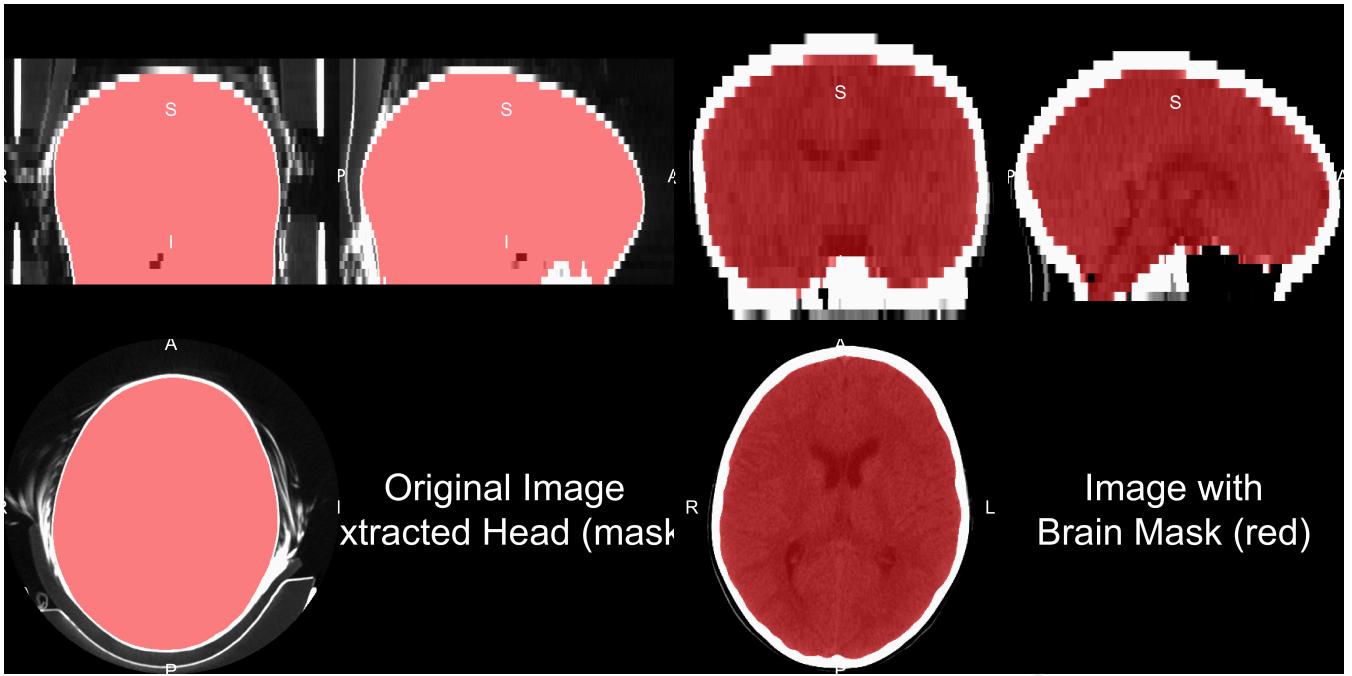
Human and Brain Extraction Results. Here we present a 5mm slice, non-contrast head CT with a soft-tissue convolution kernel. The left figure represents the CT image, showing all the areas imaged, overlaid with the extracted head mask as described in the section of "Brain Extraction in CT". The right hand side is the image overlaid with a brain mask. The brain mask was created using an adaptation of the Brain Extraction Tool (BET) from FSL, published by Muschelli et al. (2015).
